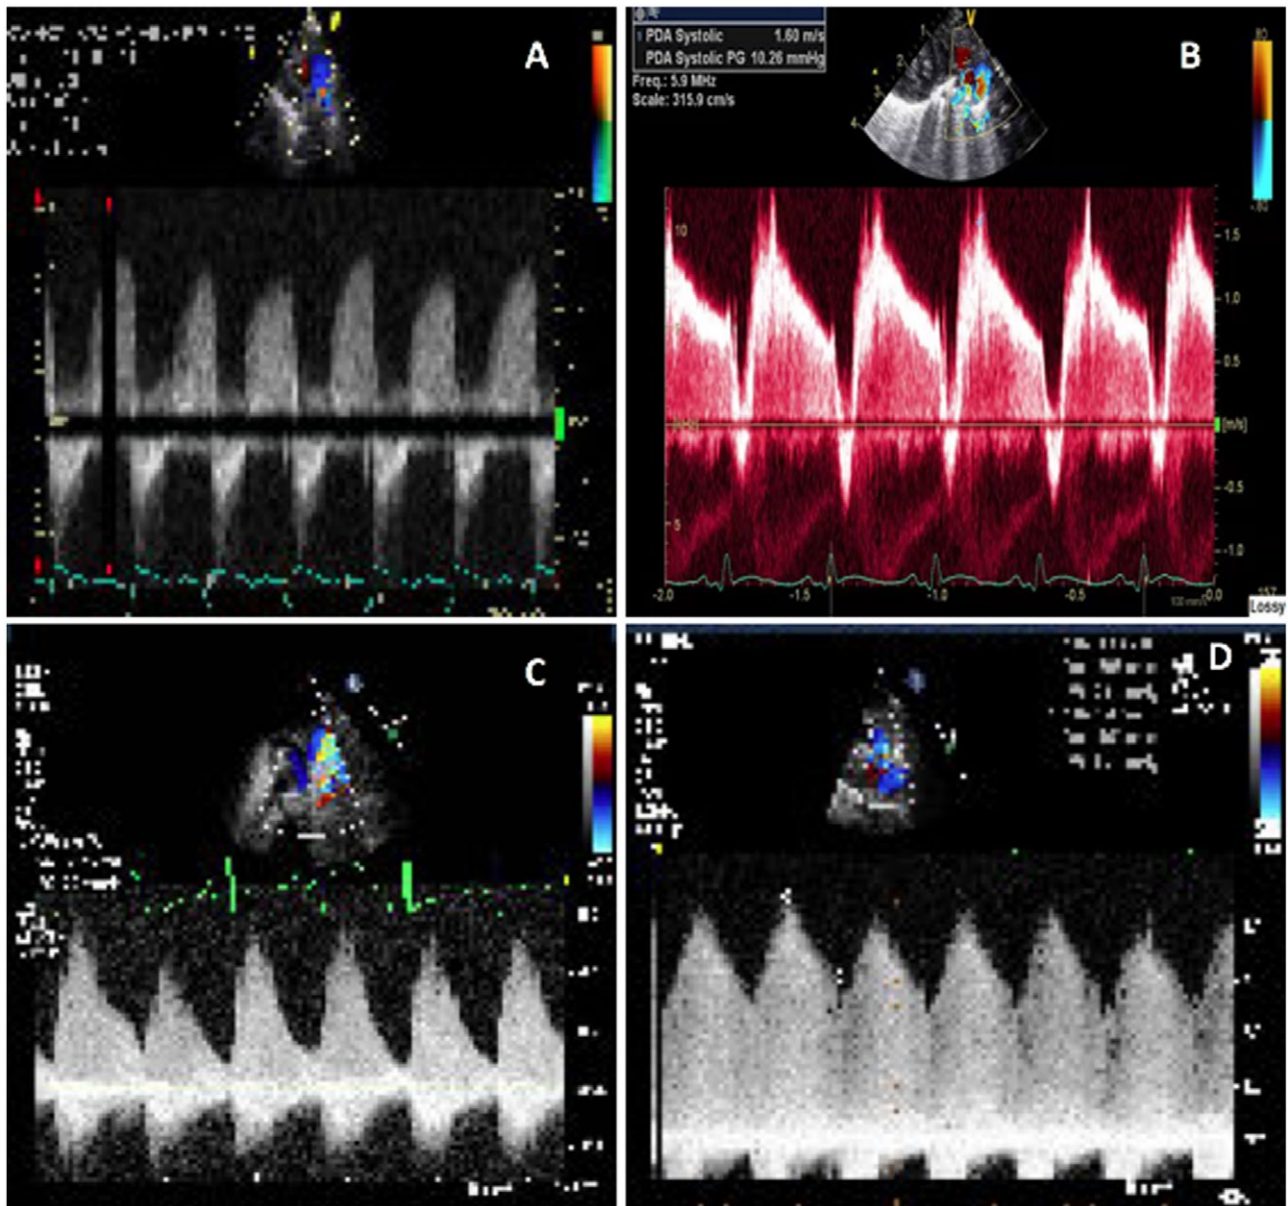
The various spectral Doppler patterns of PDA. (A) pulmonary hypertension pattern (B) growing pattern (C) pulsatile pattern (D) closing pattern. Abbreviation: PDA, patent ductus arteriosus
